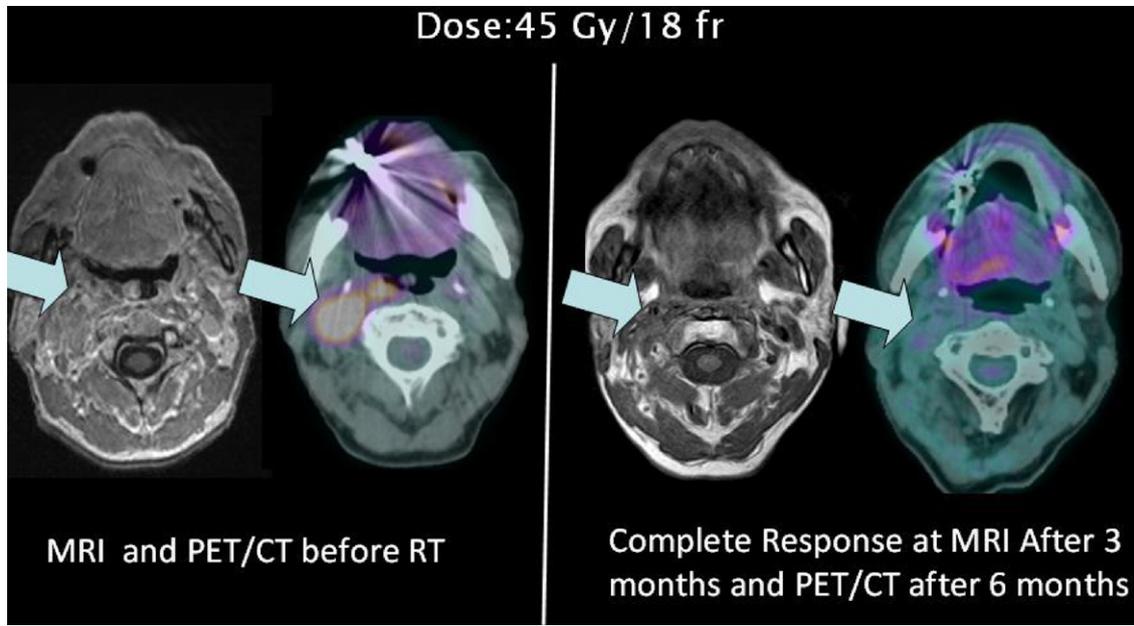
Case 4: Direct comparison of MRI and PET/CT axial images performed before re-irradiation (45 Gy in 18 fractions) and after the re-treatment, showing a complete response in the irradiated lymph nodal site of recurrence.
